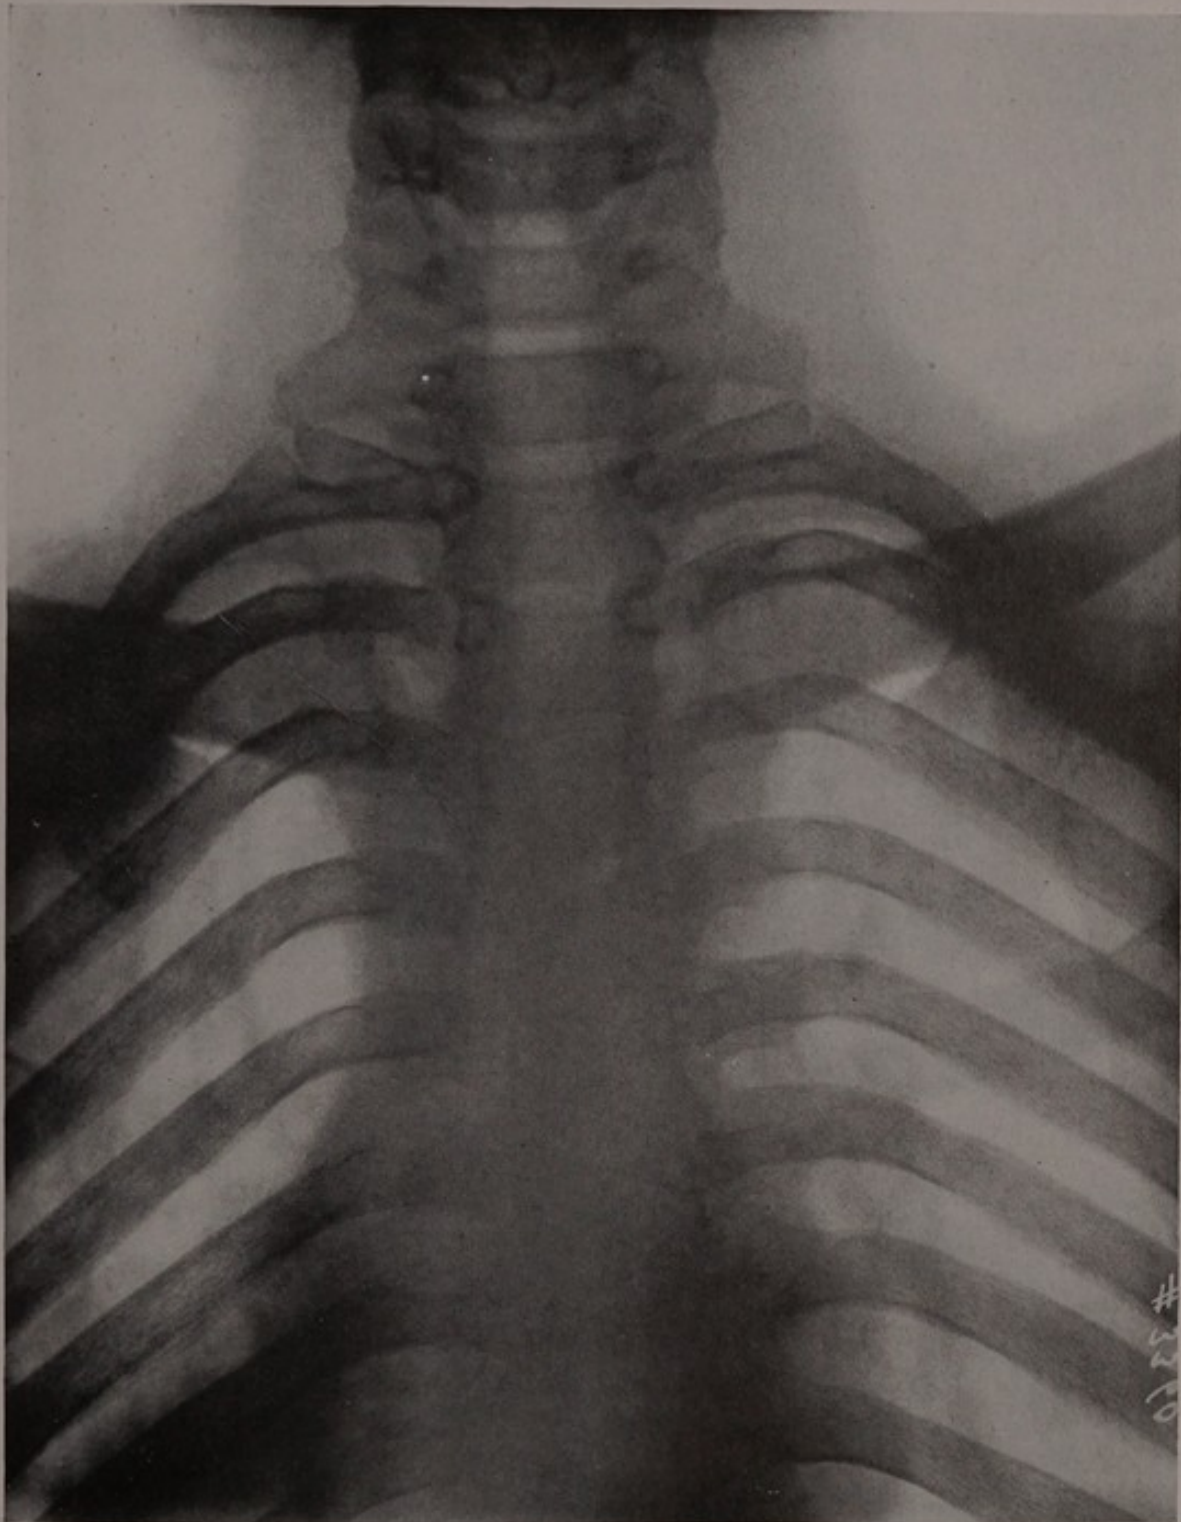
X-ray of the spine to show the amount of bone removed in a laminectomy from the sixth cervical to the third dorsal vertebrae.
